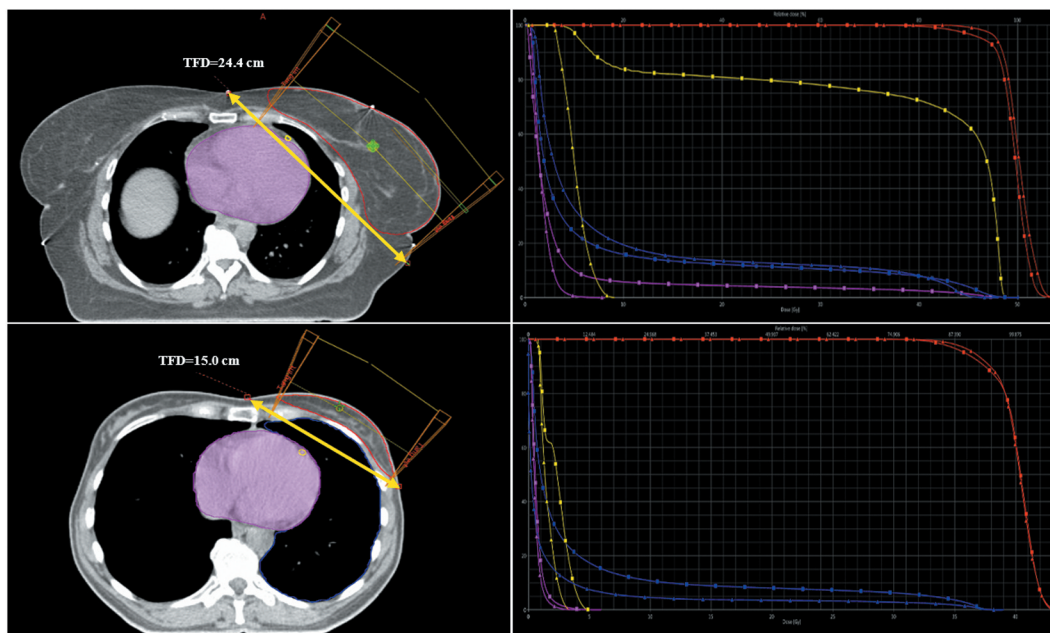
Impact of tangent fields distance (TFD) on dose to organs at risk for two representative patients. (Left) The yellow arrows, drawn on the axial projection of the free breathing CT scan, show the distance between the medial and lateral entrances at body surface of the tangent fields for two typical patients included in the study. (Right) Corresponding comparison of dose-volume histograms (DVH) in which, together with the CTV (red), the main organs at risk are shown: the heart (magenta), the LADCA (yellow) and the ipsilateral lung (blue). Squares indicate free breathing (FB) plans and triangles indicate deep inspiration breath hold (DIBH) plans. It is possible to note that the larger the CTV (1518 ml for the first patient and 254 ml for the second patient) the greater the TFD (24.4 cm versus 15.0 cm, respectively) and this results in a significant reduction, with DIBH technique (triangles), of the dose to the heart and to the LADCA for the first patient compared to the second.
